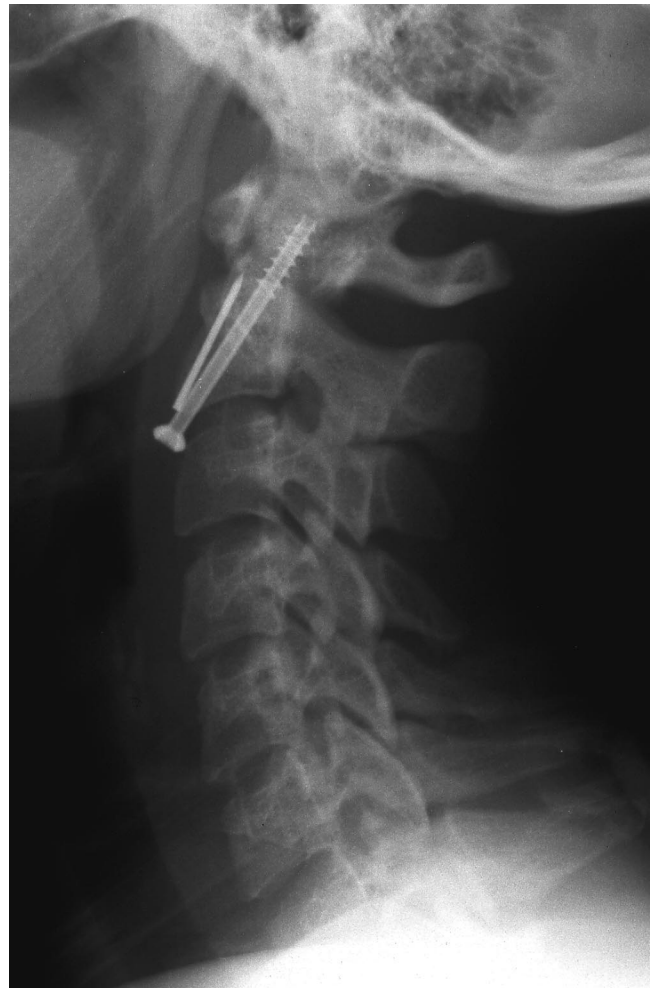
Postoperative lateral C-spine radiograph showing the implanted screw and the broken K-wire fragment.
